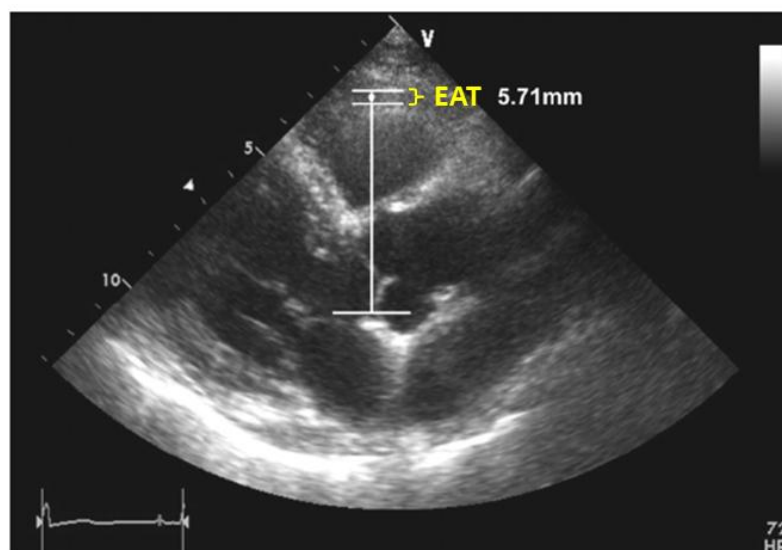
Example of measurement of EAT thickness. EAT was identified as an echo-free space in the pericardial layers on the 2-dimensional echocardiography and its thickness was measured perpendicularly on the free wall of the right ventricle at end-diastole.
